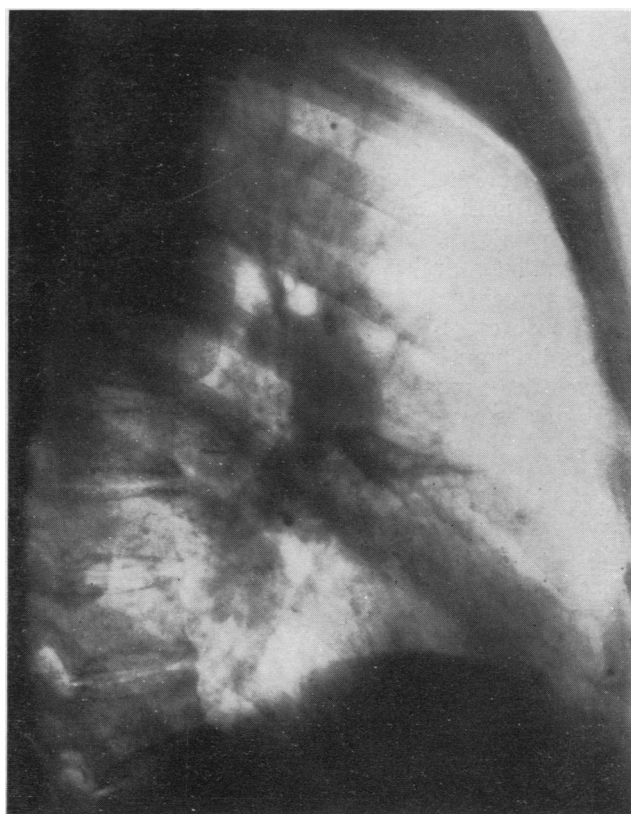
Lateral radiograph to show a contracted "honey-combed" lateral segment of the middle lobe. Calcified primary foci can be seen in the lung and also at least one calcified gland.
